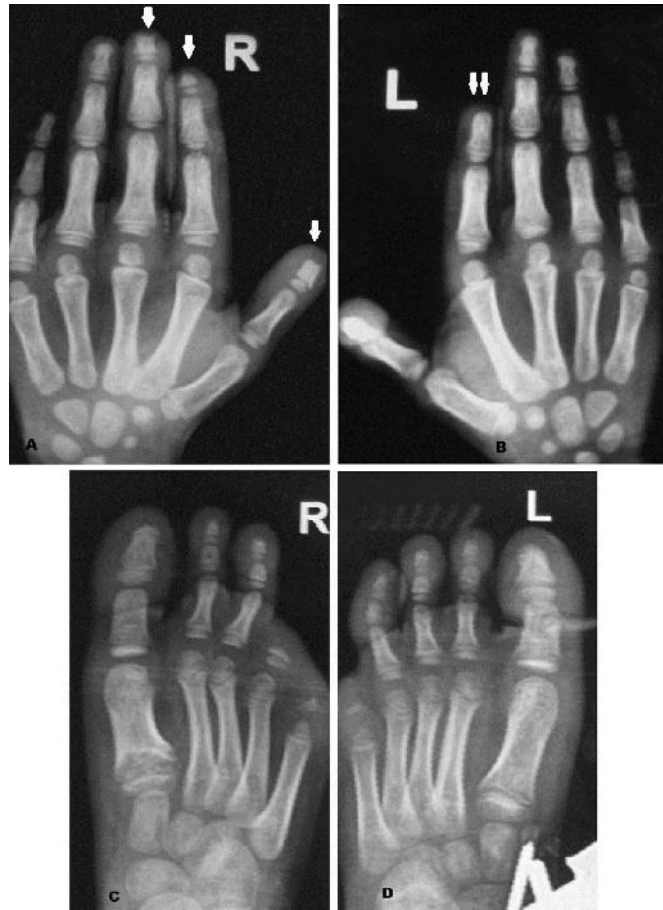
Radiographs of hands and feet A. Right hand showing osteoacrolysis of distal phalanx (arrow) of thumb, index finger and middle finger. B. Left hand showing missing terminal phalanx of index finger (double arrow). C. Right foot showing absent 4th and 5th toes and osteoacrolysis of terminal phalanx of 3rd toe. D. Left foot with missing 5th toe
